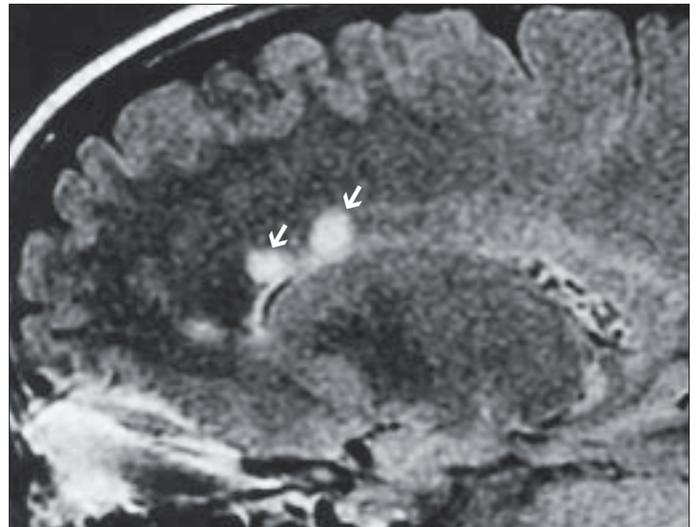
Sagittal FLAIR MR image demonstrates multiple ovoid periventricular lesions (arrows).
